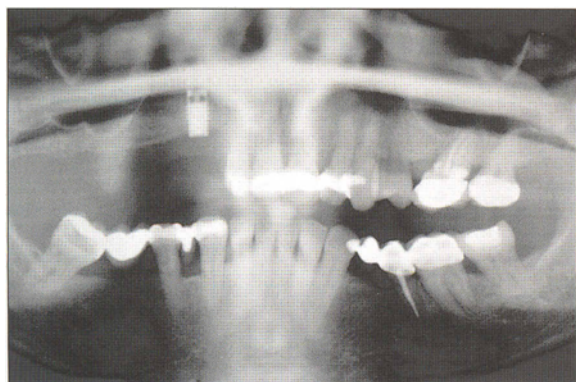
The panoramic radiograph reveals a non-storable hollow-basket implant in the maxillary right posterior area and a pneumatized sinus. The patient had a failed cantilevered implant prosthesis.
